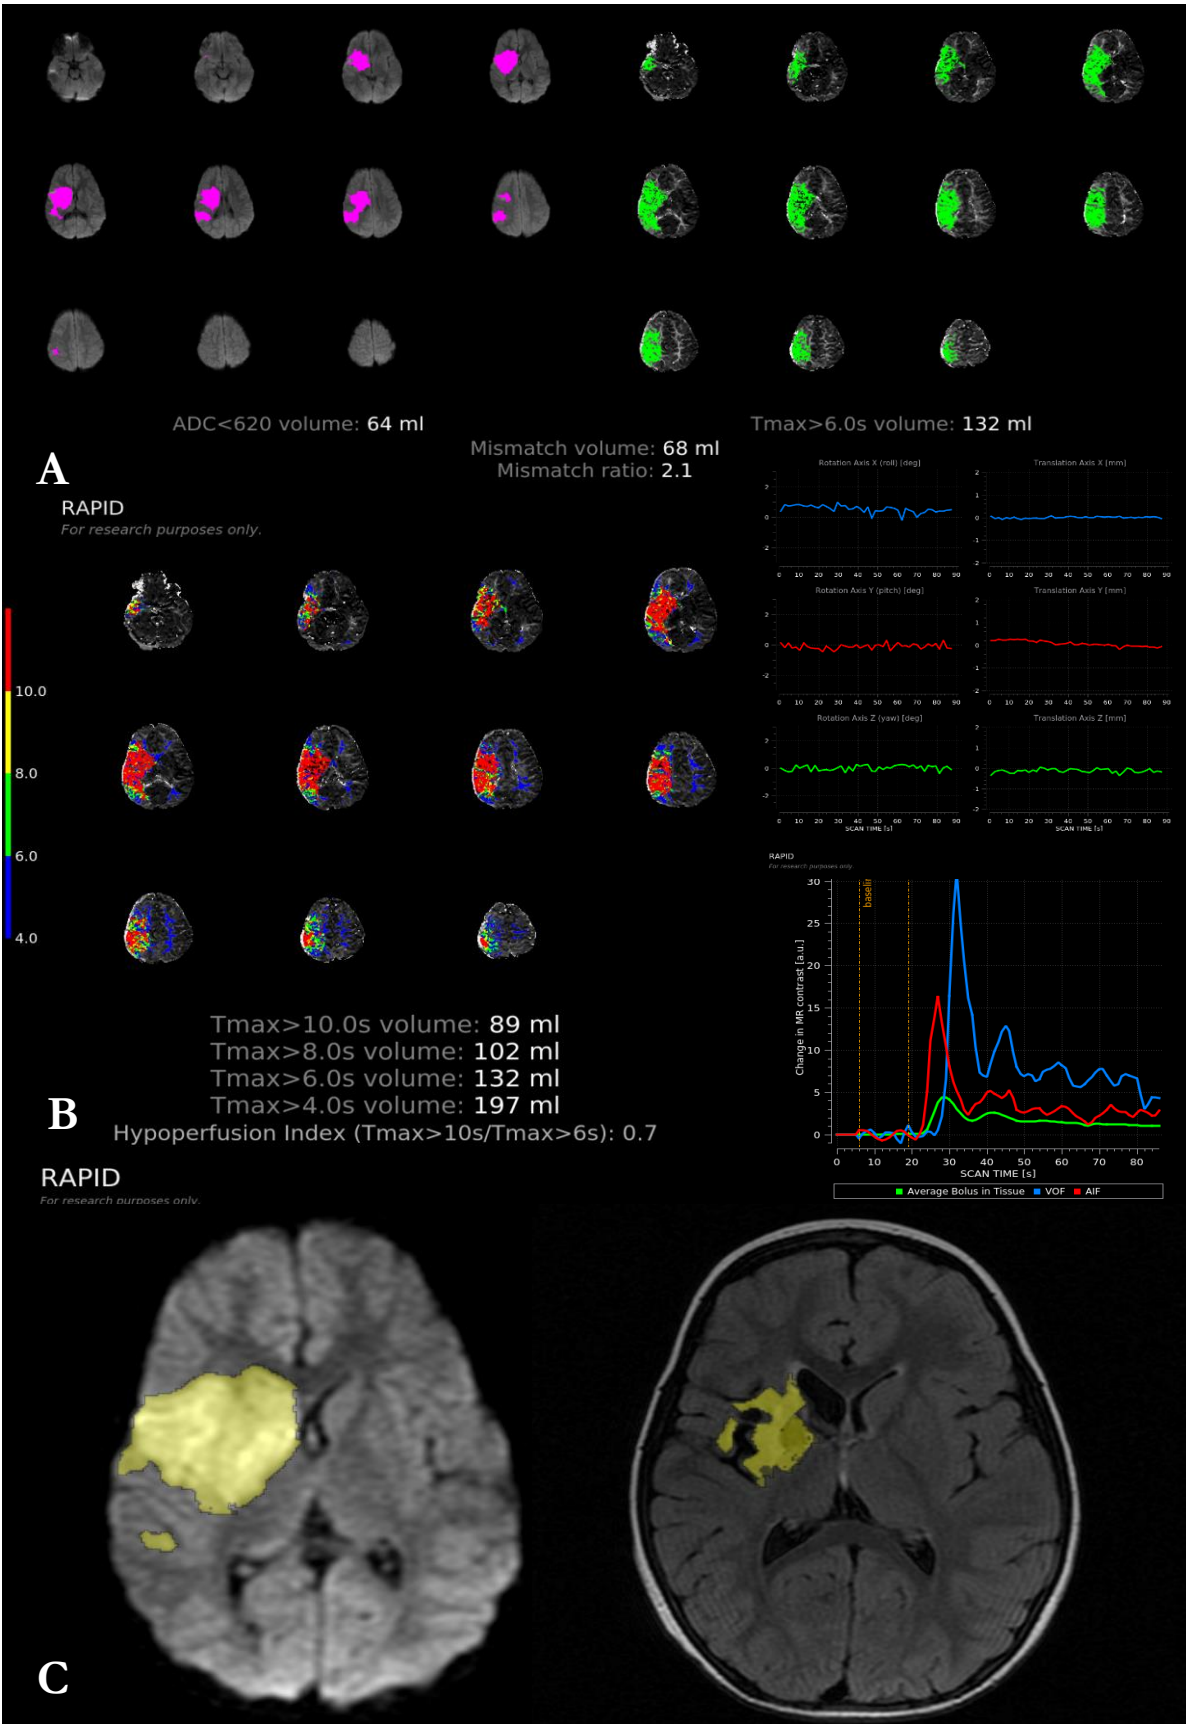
RAPID output and manual segmentation Case study 1. (A) Automated mismatch segmentation core (left) hypoperfusion (right) using standard RAPID thresholds (B) Alternate  $T_{max}$  thresholds, head motion, and AIF curves. (C) Manual segmentation of acute DWI lesion 62.5mls (left) and chronic T2 FLAIR lesion 9.2mls (right)
